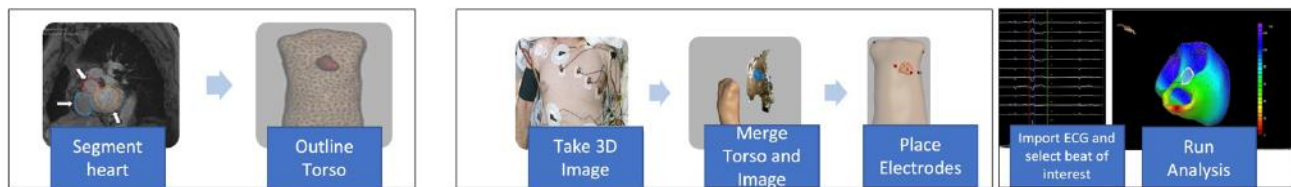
Amycard system methodology from left to right. Torso leads connected to a multichannel amplifier recorder. Thorax and heart CT scan. Reconstruction of the patient's torso and heart geometry and epicardial and endocardial activation map displaying the earliest activated point (red dot)
